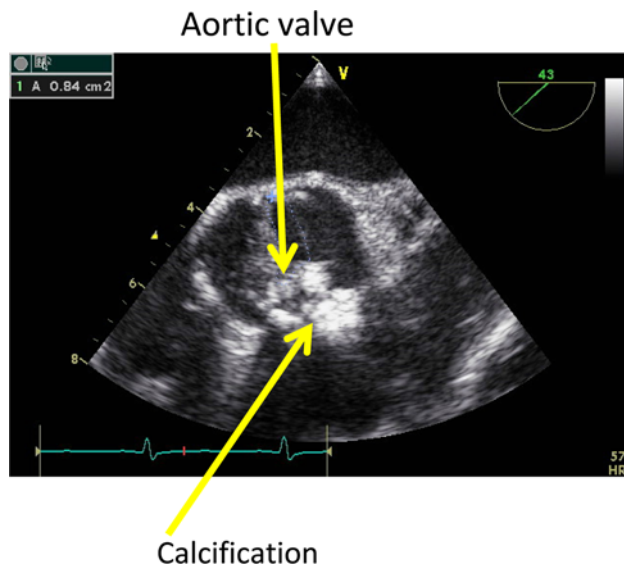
Transesophageal echocardiography during the operation. Calcified degeneration in bicuspid aortic valve is shown
